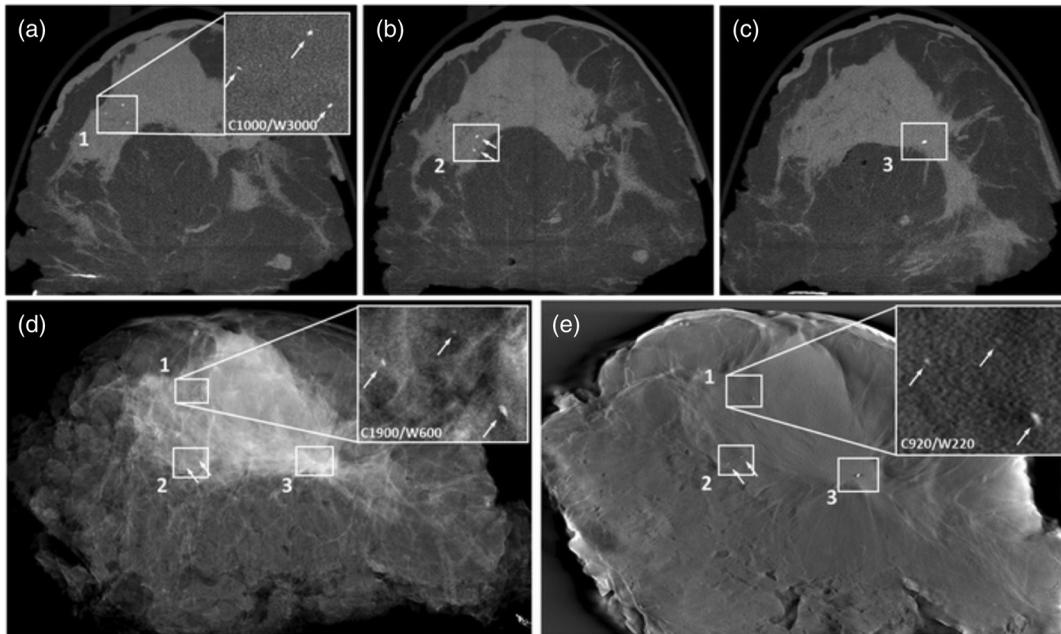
Multiscale imaging with SPC- μ CT depicts tissue in 3-D with higher resolution and soft-tissue contrast than 2-D single-scale clinical imaging. Panels (a)–(c) show slices from an SPC- μ CT volume. Panel (d) shows a digital mammogram while panel (e) shows a breast tomosynthesis image. There are microcalcifications on each of these images that are pointed to by the white arrows, and specified in a region of interest. The volume in (a–c) has high contrast and locality due to its mesoscale resolution across a whole-breast 3-D volume. © European Society of Radiology 2016.⁶⁰
